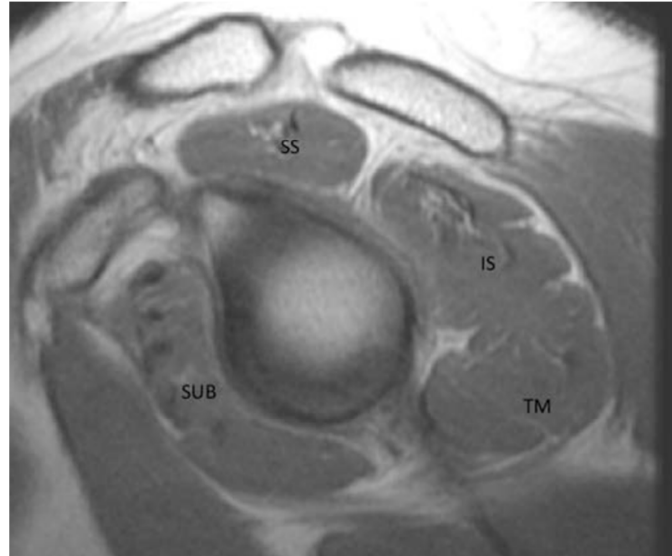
Normal rotator cuff muscles in cross section on a sagittal T1-weighted MRI image at the level of the coracoid. SS- supraspinatus, IS – infraspinatus, TM – teres minor, SUB – subscapularis (2)
